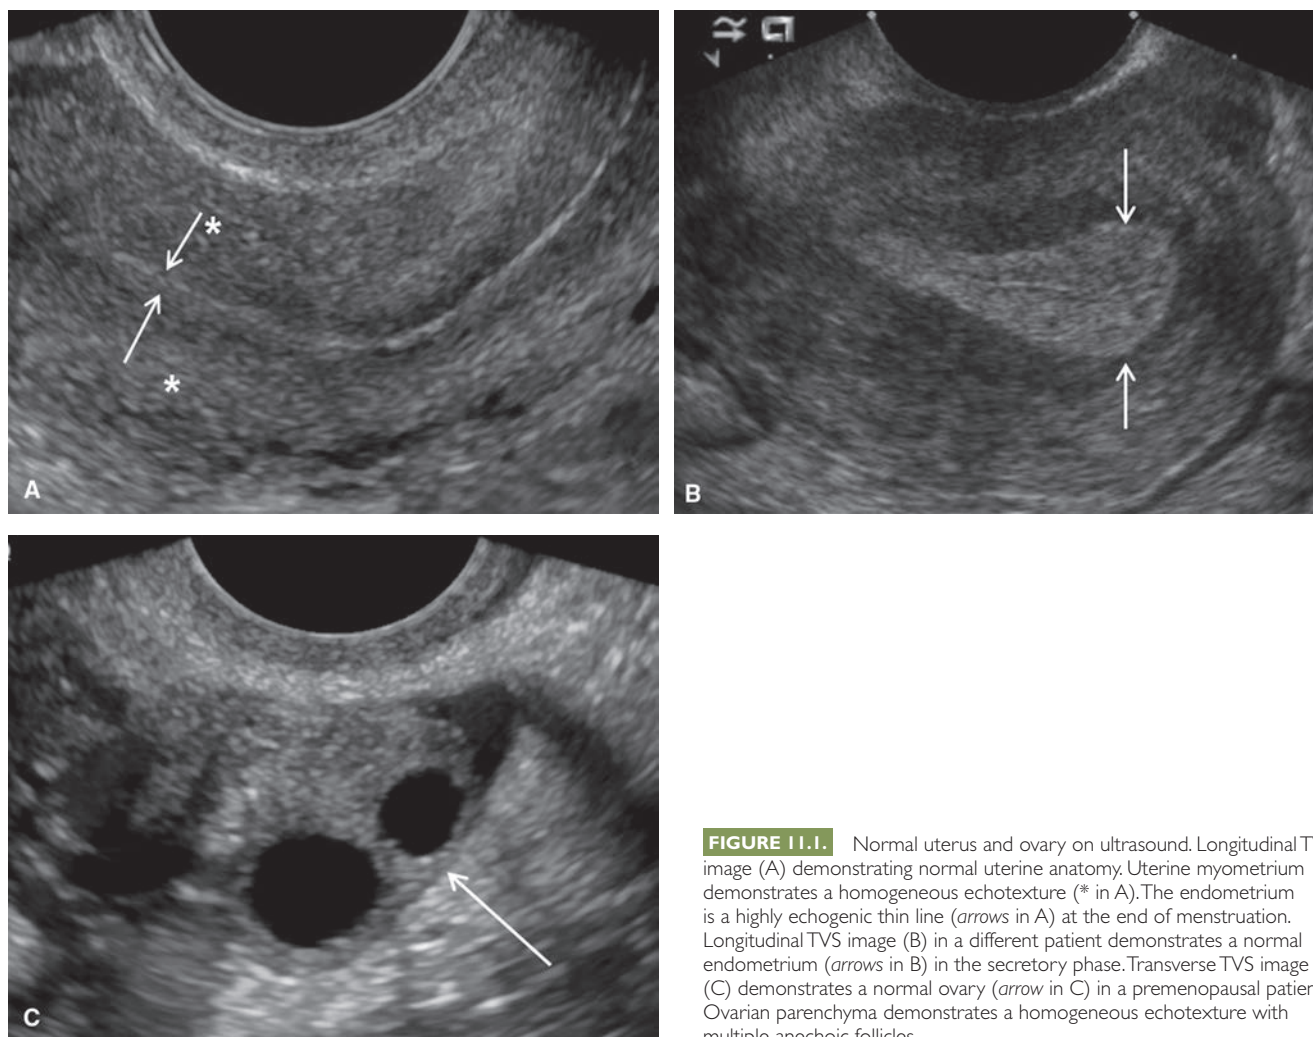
Normal uterus and ovary on ultrasound. Longitudinal TVS image (A) demonstrating normal uterine anatomy. Uterine myometrium demonstrates a homogeneous echotexture (* in A). The endometrium is a highly echogenic thin line (arrows in A) at the end of menstruation. Longitudinal TVS image (B) in a different patient demonstrates a normal endometrium (arrows in B) in the secretory phase. Transverse TVS image (C) demonstrates a normal ovary (arrow in C) in a premenopausal patient. Ovarian parenchyma demonstrates a homogeneous echotexture with multiple anechoic follicles.
